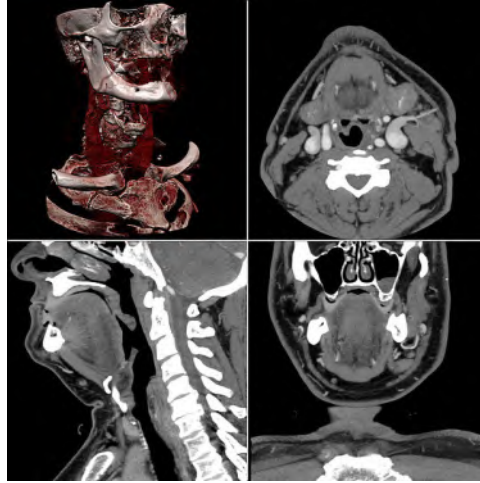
A CT scan of the neck area. The top left image is a 3D rendering, and the remaining pictures are cross-sectional slices through the 3D image. The principle is the same as with X-ray imaging, but we can see that much more detailed information is visible. [Image obtained from [2], used under a Creative Commons Attribution-ShareAlike license]
